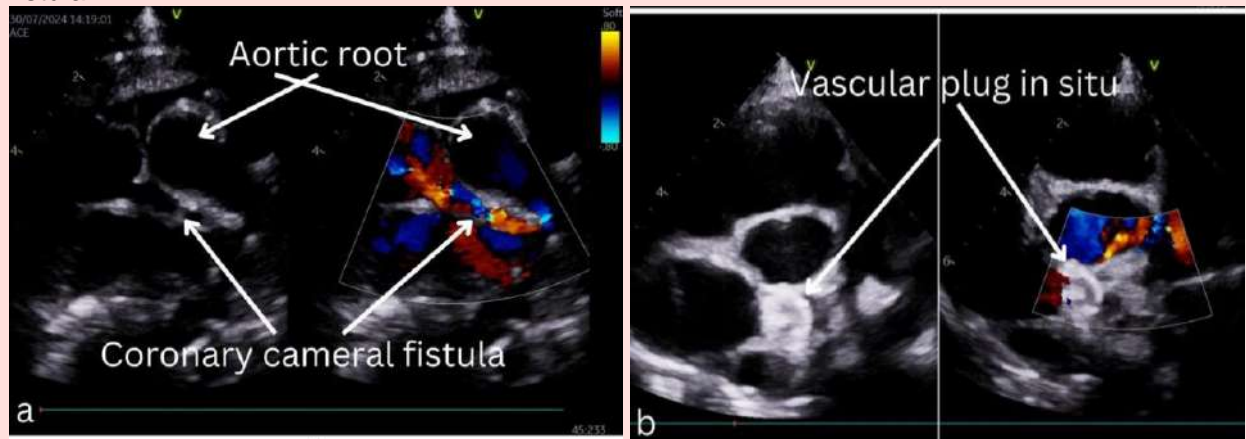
Pre and post-procedure 2D-Echocardiography. a. Pre-procedure 2D Echocardiography showing dilated left main coronary artery continuing as LCX and dilated fistulous tract draining in the right atrium just after the IAS. b. Post-procedure 2D Echocardiography showing a Vascular plug in situ completely occluding the coronary cameral fistula.
